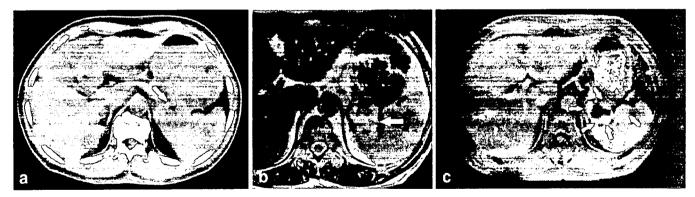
A 72-year-old man with abdominal pain. a Unenhanced CT shows a heterogeneous mass in the gastric body that contains central gas (arrow). b Transverse T2-weghted fast spin echo MRI (2550/120) shows central cystic regions of high signal intensity interspersed with septumlike structures of low signal intensity
